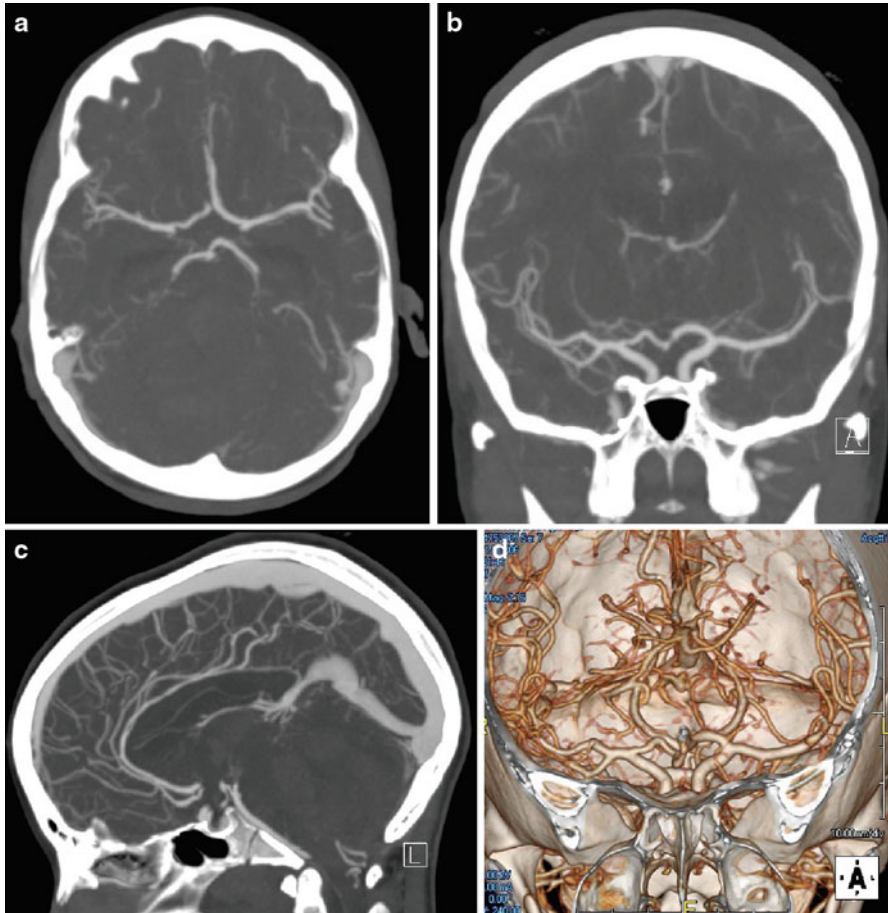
CT angiogram. 9-year-old female with intracranial hemorrhage. These are images from a CT angiogram with contrast in the axial plane (a), coronal (b), and sagittal planes (c). 3D reconstructions of the vasculature can also be made from the original acquisition (d)
